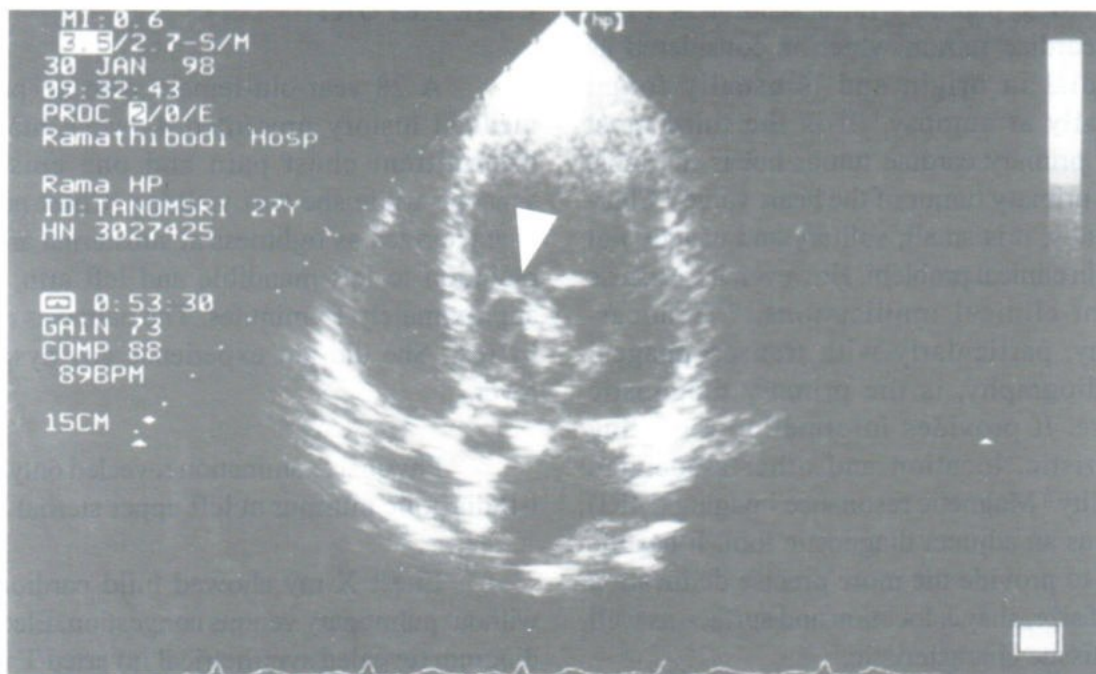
Transthoracic echocardiography demonstrated an echogenic mass at anterior leaflet of mitral valve.
